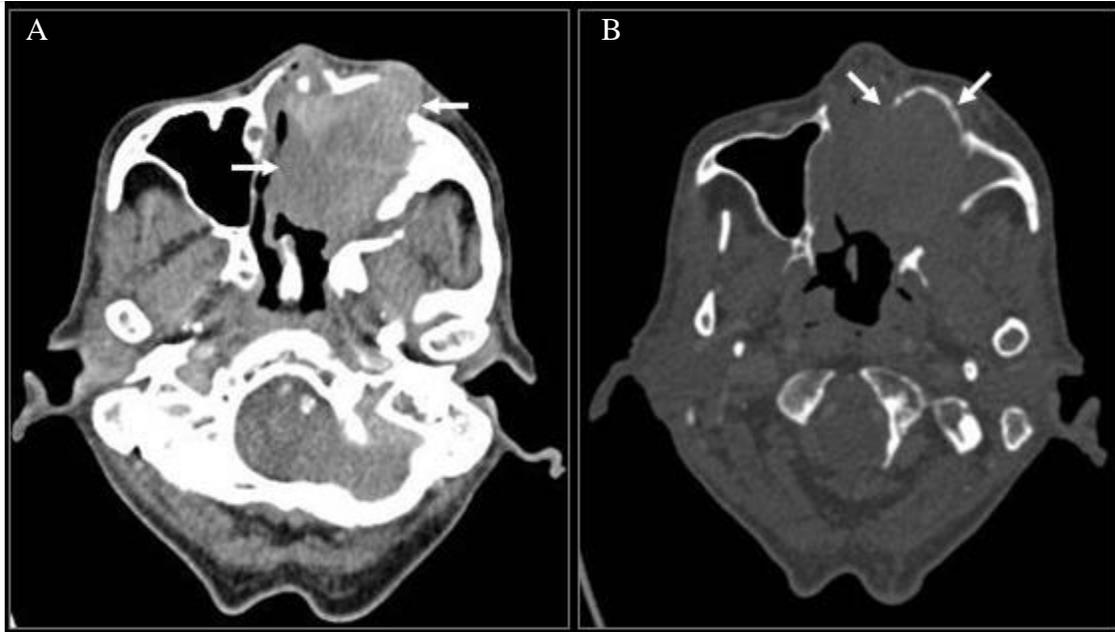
Axial images from contrast-enhanced CT of head and neck in (A) soft tissue window and (B) bone window demonstrating the left maxillary tumor (black arrows) with extensive local infiltration and destruction.
